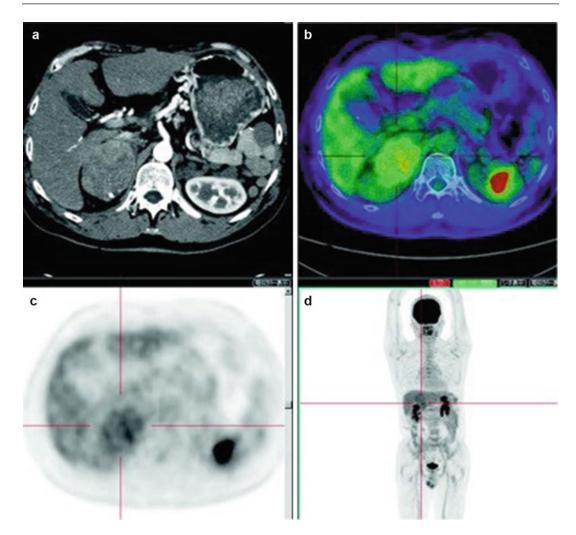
An adrenal metastasis of hepatoma. A male with history of HCC therapy with AFP elevation but no intrahepatic recurrence. Contrast-enhanced CT at arterial phase shows early enhance on right enlarged adrenal gland (a). [¹⁸F]FDG-PET/CT shows moderate hyperglycolysis at
